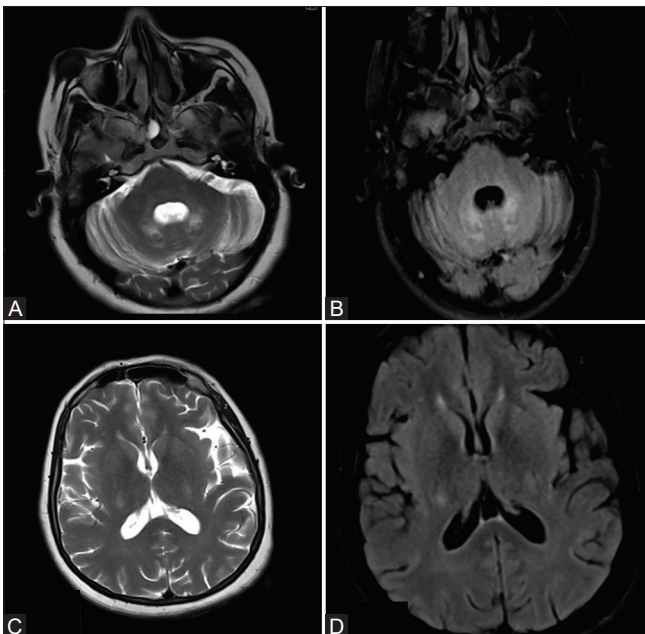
(A-D): Axial T2-weighted and FLAIR images (A and B) reveal hyperintensity of bilateral dentate nuclei and deep cerebellar white matter. Hyperintensity of posterior limb of bilateral internal capsules is also seen on T2-weighted and FLAIR images (C and D)
